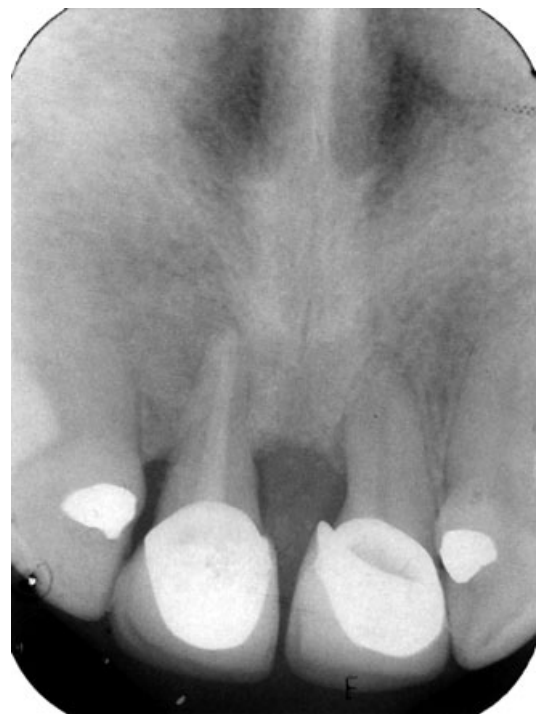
The marked bone filling is observed in periapical radiograph after 4 years.
